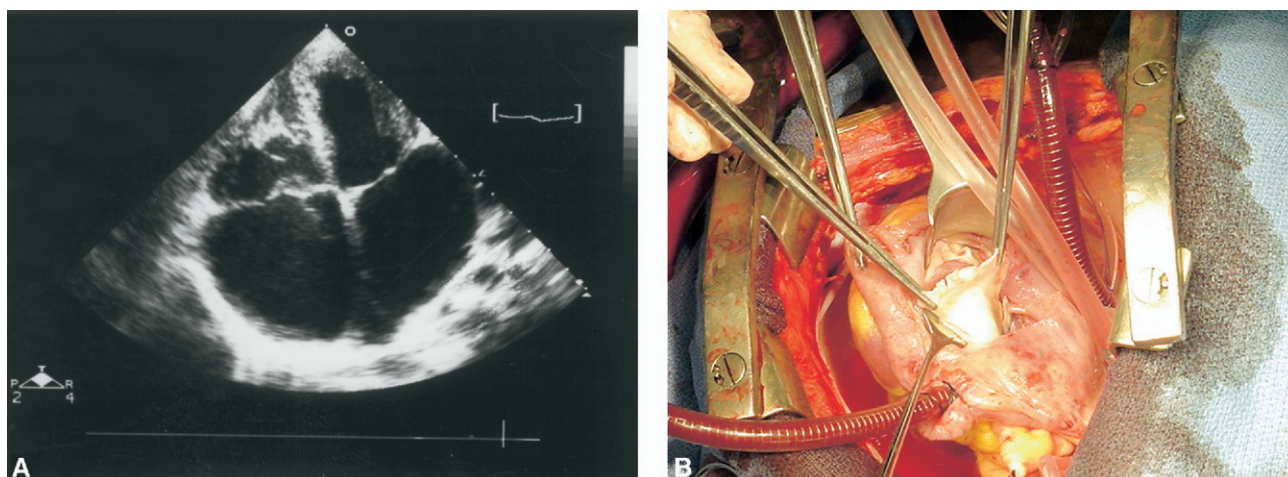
A, Echocardiogram showing obliteration of the trabecular part of the right ventricle in a case of bilateral endomyocardial fibrosis. Notice fibrosis in the apex of the left ventricle and dilatation of both atria. B, Through sharp dissection, a plane of cleavage is created, allowing the separation of the fibrous tissue from the myocardium. Excision of the fibrotic tissue is done as a block, revealing a healthy myocardium underneath it.
